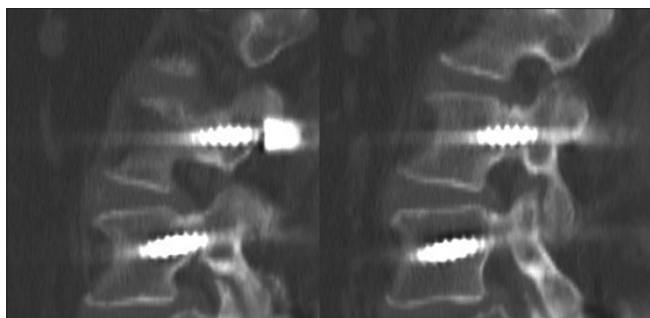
(right) Nine-month postoperative axial computed tomography revealing fusion at L2 bilaterally and resolution of sclerosis in right L3 pedicle
